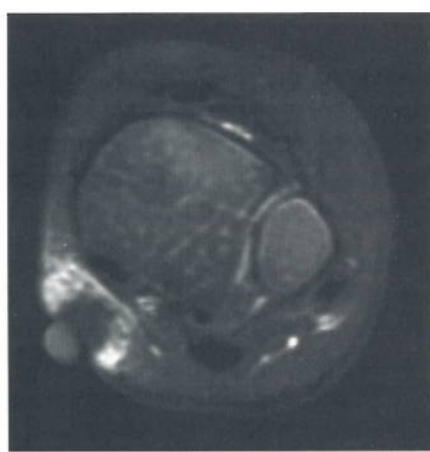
The post-gadolinium transverse T1-weighted FatSat scan demonstrated a more heterogeneous soft-tissue mass, which lead to a very confusing interpretation.
